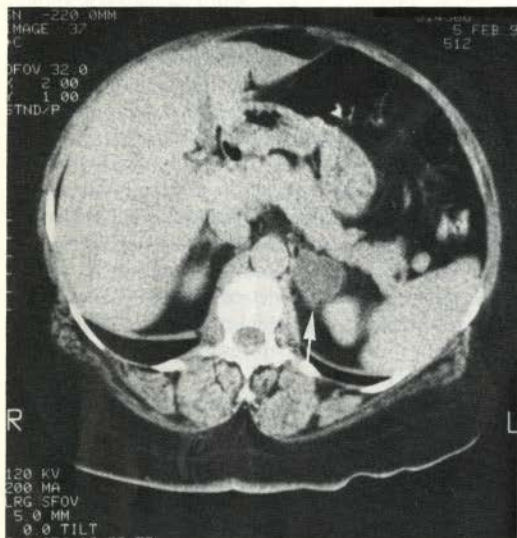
CT scan of the adrenals in a female with hypertension, long standing hypokalemia, suppressed PRA and high aldosterone levels. There is a large homogeneous mass in the left adrenal (see arrow).
